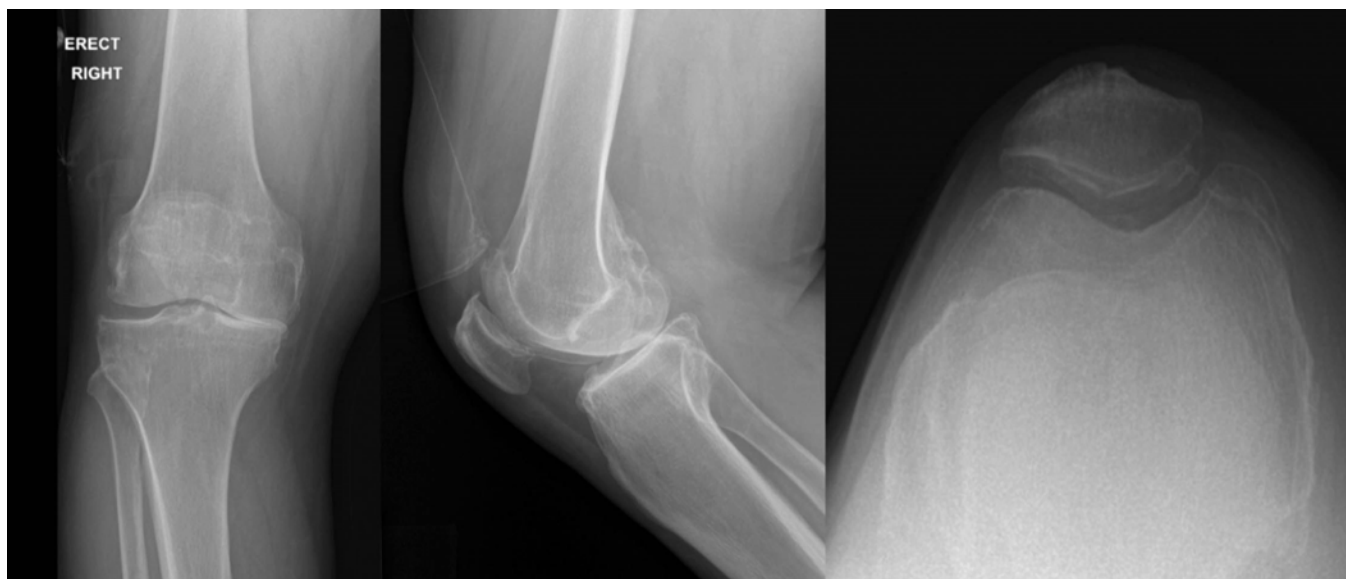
Pre-operative AP, lateral and merchant view radiographs of a patient with isolated medial compartment arthritis.
